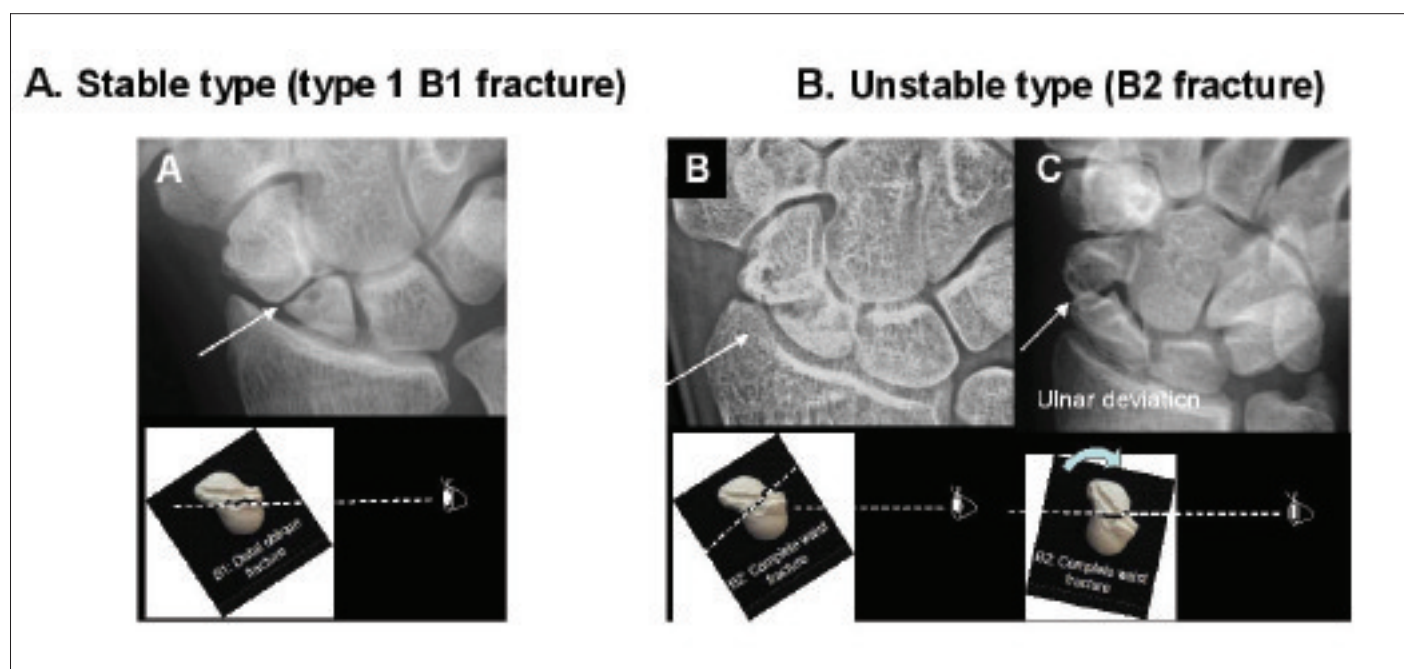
P-A view. A) In Type 1 B1 (stable fracture), fracture line usually is seen clearly because fracture line runs almost parallel to the X-ray beam. B) and C) In B2 (mobile fracture), fracture line is not often visible in neutral position because fracture line runs obliquely relative to the x-ray beam. In a P-A view with ulnar deviated position, however, fracture line becomes visible because scaphoid rotates dorsally.
